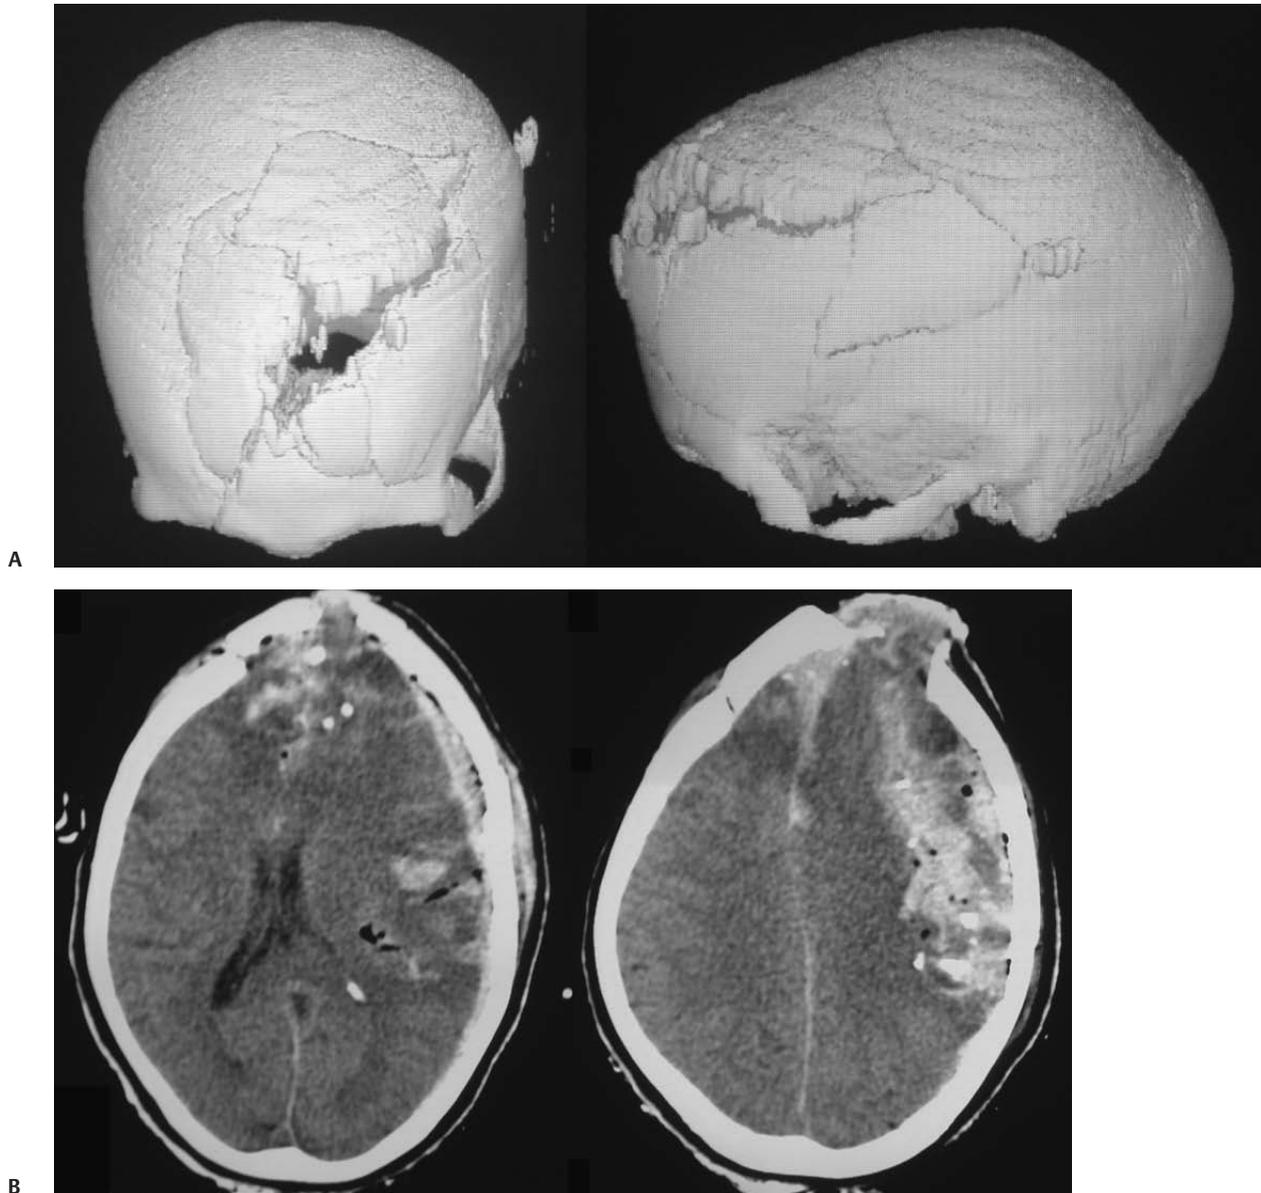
(A) This civilian victim of a suspected AK-47 perforating round was without body armor and was evacuated to the combat support hospital within 20 minutes of her injury localizing on examination with open, herniating brain through a complex scalp defect. (B) Computed tomography demonstrated evidence of global deformity with “bursting
